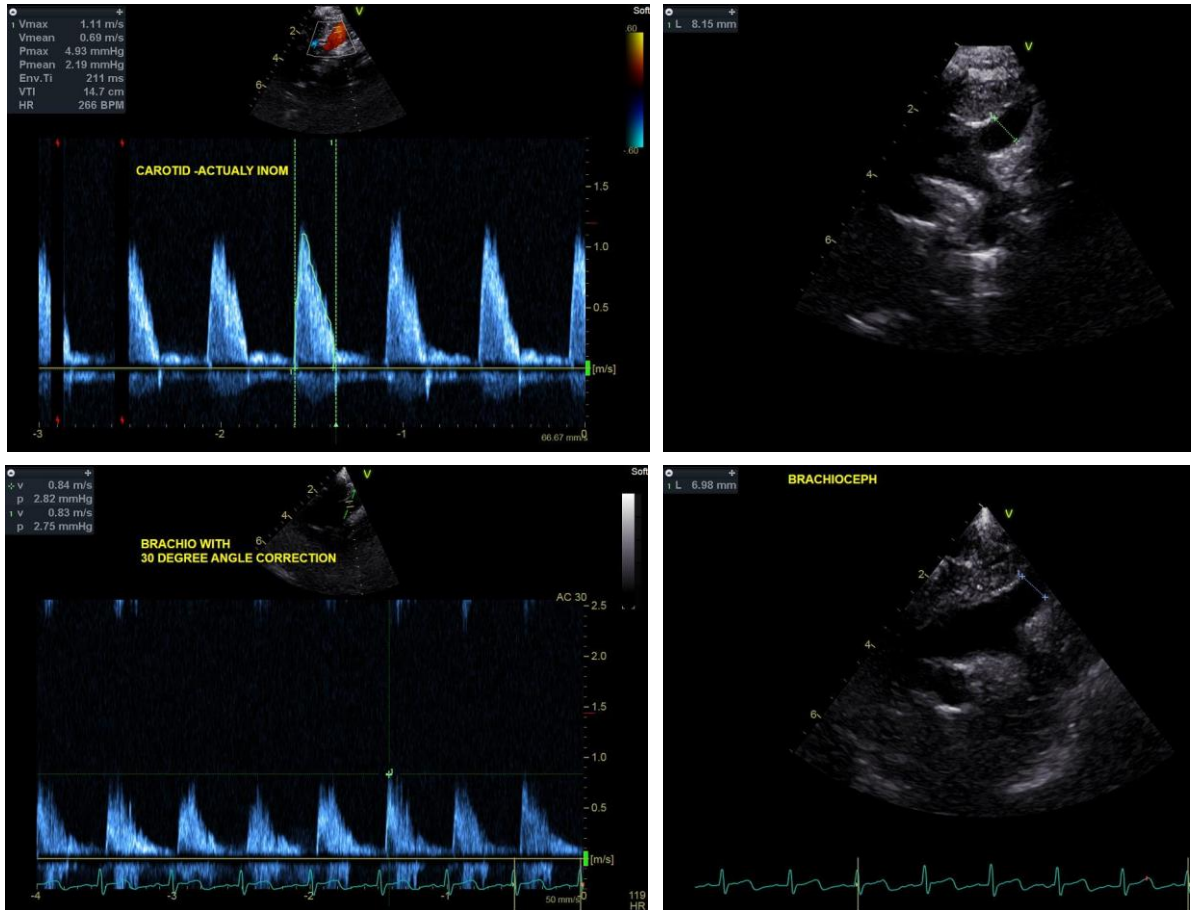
Innominate echocardiography results for both pre- (top row) and post- intervention (bottom row) instances.
